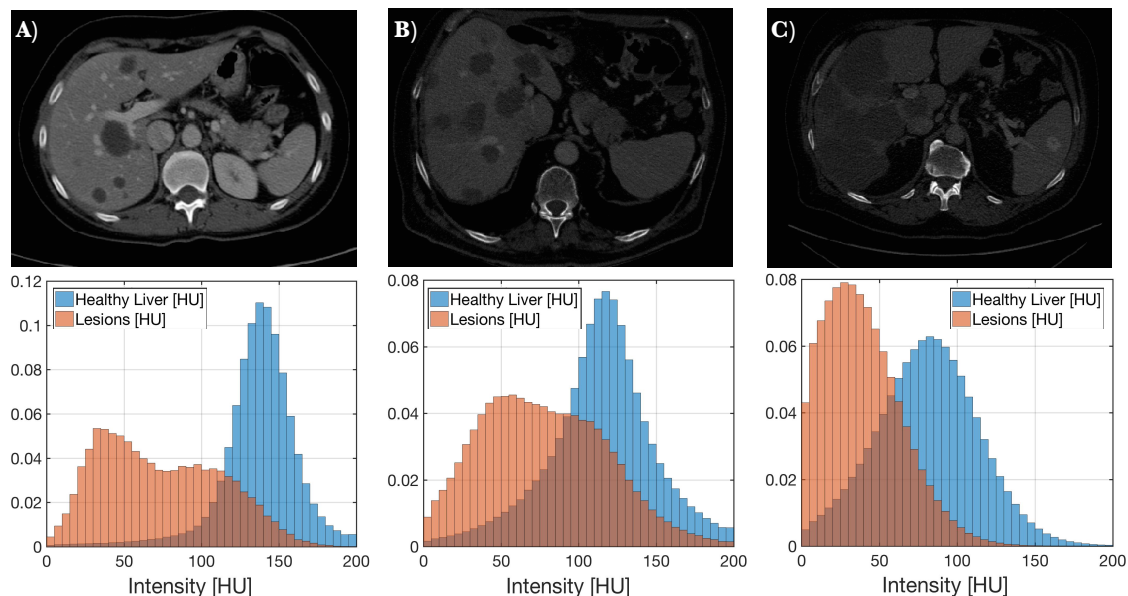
Abdominal CT scans of three patients with liver lesions (Top). All scans are clipped to range $[-100,1000]$ HU. Bottom: the corresponding normalised histograms showing the distribution of image intensities in the lesions (orange) and in the healthy part of the liver (blue). Low liver-lesion contrast is evident also from the significant overlap of the histograms. The size, shape, image intensities, and width of the mixed liver-lesion interface vary among the different lesions.
